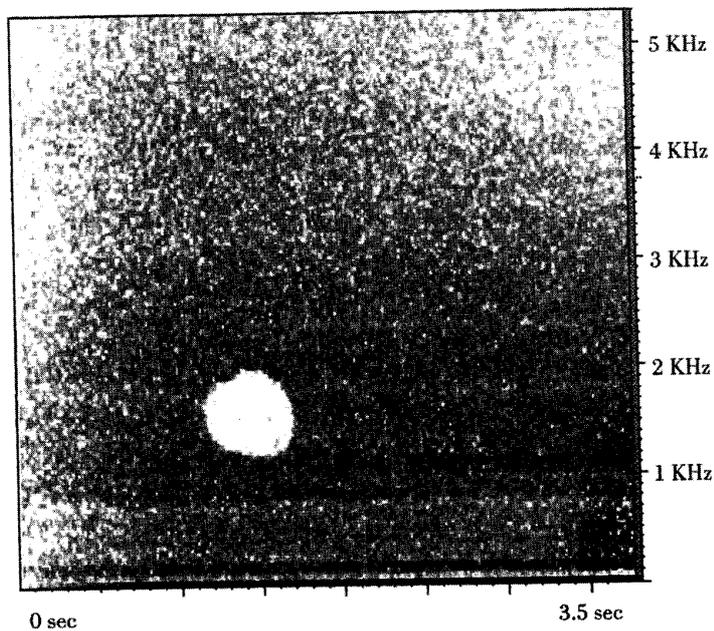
A hole in a broadband sound, sculpted by a sonogram filter. We can carve time-frequency gaps on different time scales.
